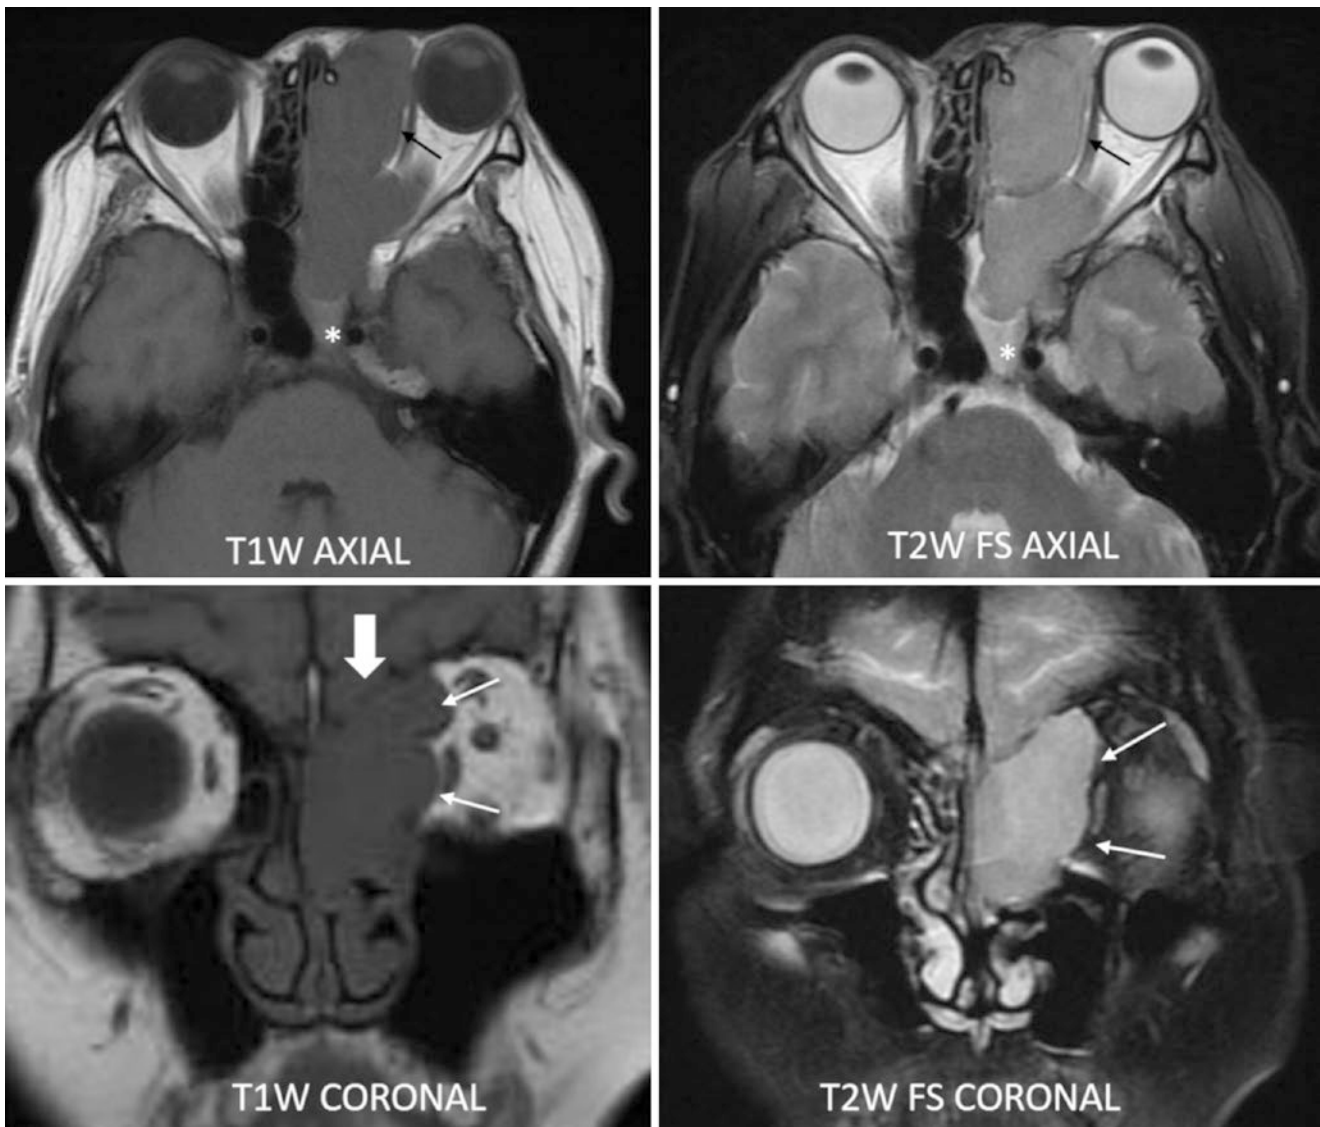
MRI scan of the sinuses shows a smooth, lobulated, expansile mass, almost isointense to grey matter on T1 and T2w sequences, filling the left ethmoidal, frontal and sphenoidal sinuses, and nasal cavity. Note the expansion into the left orbit pushing the medial rectus and eye ball
